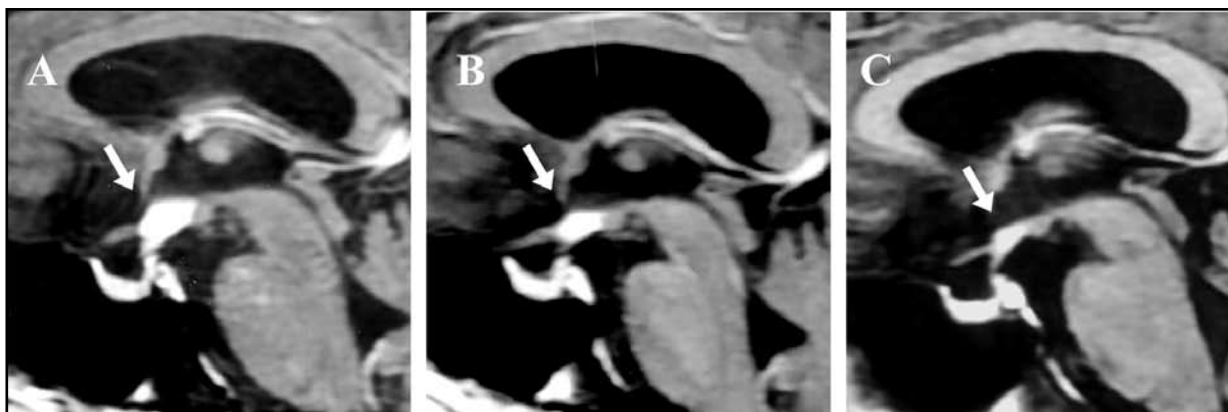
MRI sagittal T1-weighted image. A: Before prednisone therapy. B: 1 month later. C: 6 months later.
